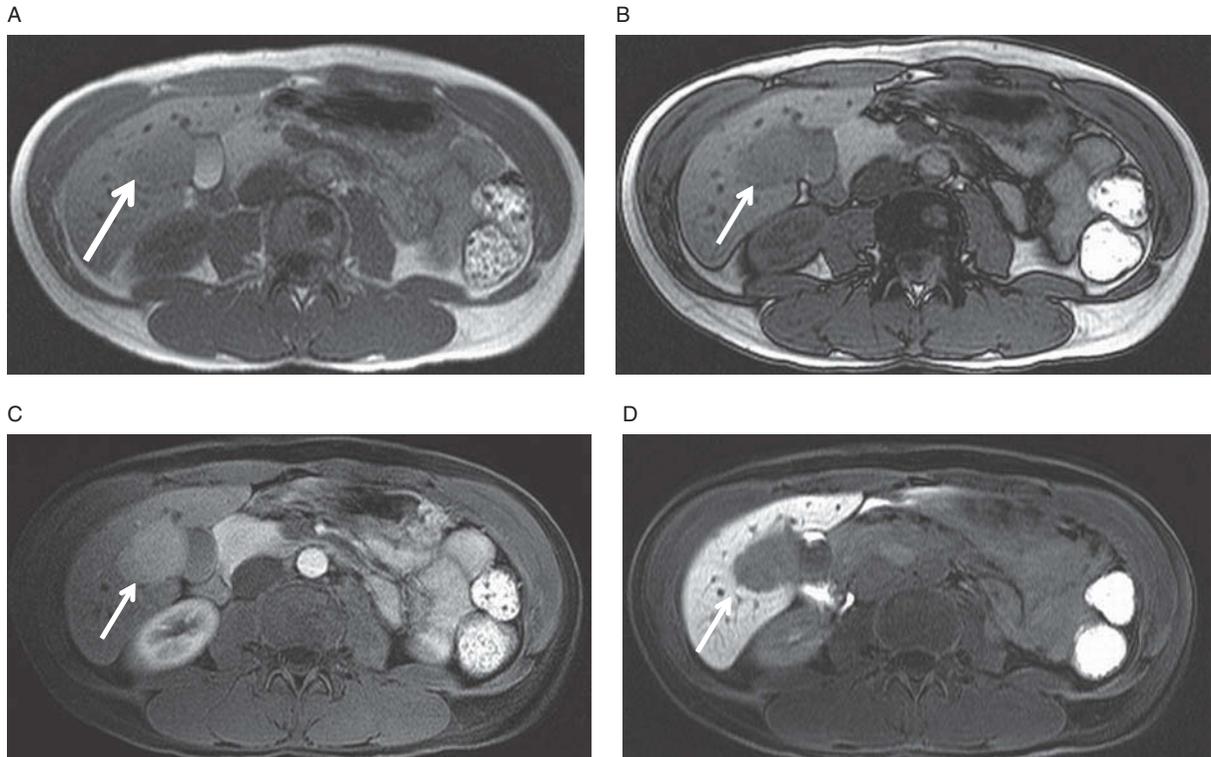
Hepatic adenoma. Hypointense liver lesion (arrows) does not significantly change in signal from in-phase image (A) to out-of-phase image (B). Gadoxetate disodium was administered IV. The lesion avidly enhances on arterial phase T1-weighted, fat-saturated post-contrast image (arrow, C), but completely washes-out on 20 minute delayed image (D). FNH would retain the contrast.
